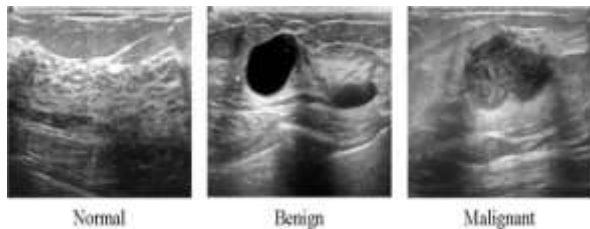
Examples of ultrasound image data in the database.
